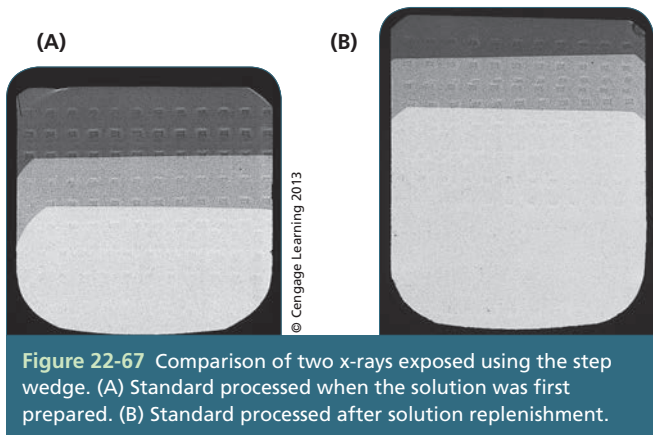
Comparison of two x-rays exposed using the step wedge. (A) Standard processed when the solution was first prepared. (B) Standard processed after solution replenishment.
